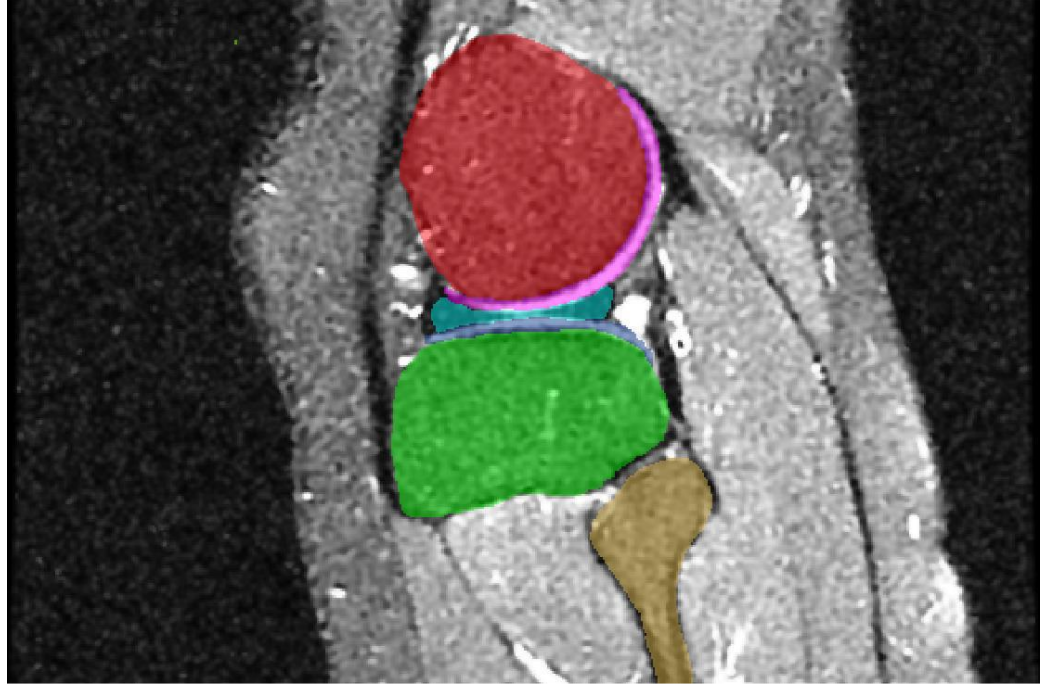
Fully segmented MRI sequence image of 2016Nov05-01R. Sagittal plane view. Femur (red), femoral cartilage (pink), lateral meniscus (teal), lateral tibial cartilage (blue), tibia (green) and fibula (tan)[39]
